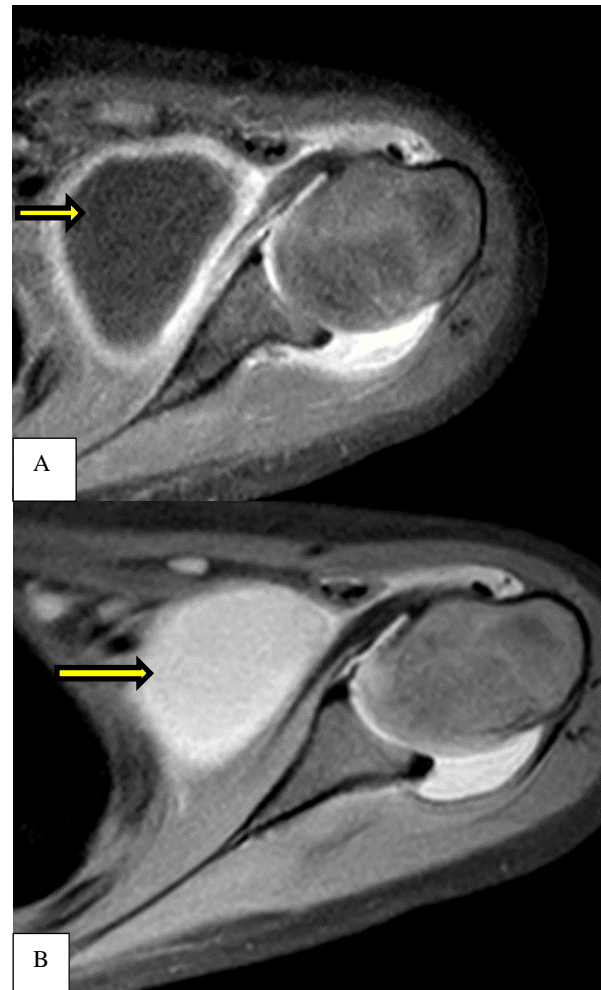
(A and B): MRI scan showing marked subacromial-subdeltoid and sub coracoid bursitis and tenosynovitis of long head of biceps tendon.¹²
